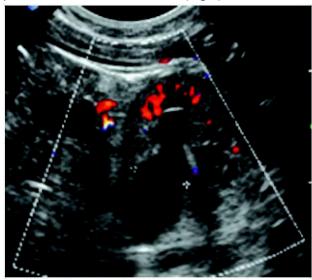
Seven days-old neonate with mild left HN. Axial US & Doppler image showed RPD =9mm.
